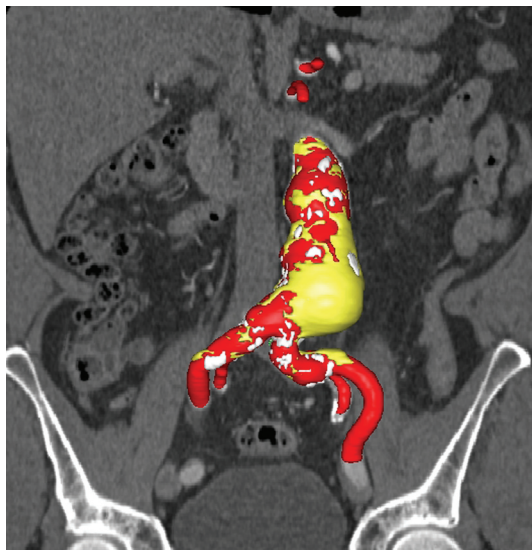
CTA, Volume Rendering
